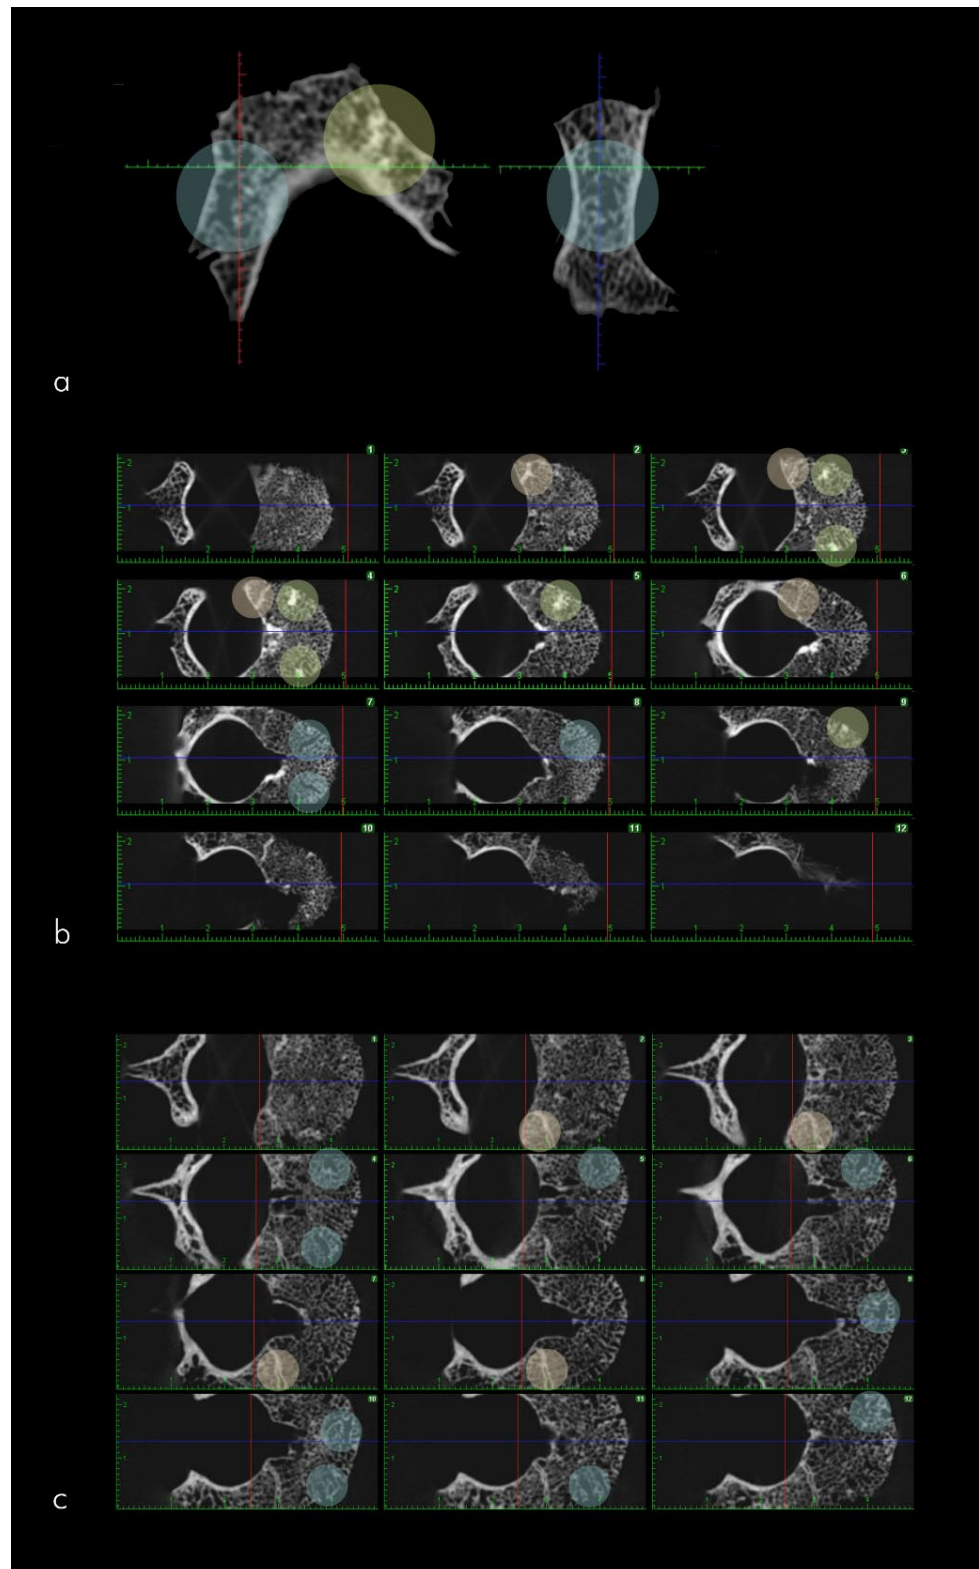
CT acquisitions of select pathological bones of ISZ2 are depicted. In (a), the pars basilaris exhibits areas of bone rarefaction indicated by blue circles, along with smaller regions of denser bone near the lateral angle highlighted by a yellow circle. In (b,c), the T9 and L2 vertebrae, respectively, demonstrate normal ossification patterns, with dense bone present at the border between the vertebral body and peduncle denoted by orange circles. Additionally, increased bone density is observed within the vertebral body, represented by yellow circles, and grooves are visible within the vertebral body indicated by blue circles.
